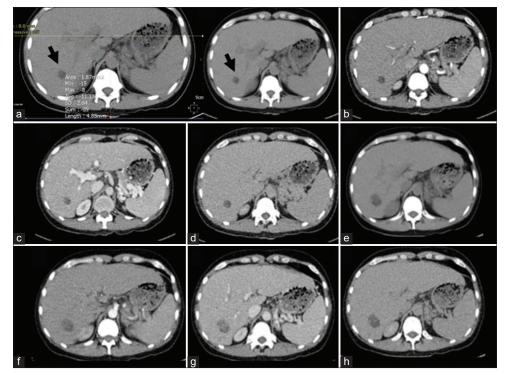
A 64-year-old male with hepatocellular carcinoma presenting with diarrhea. (a-d) multiphase abdominal CT scan showed a nodule (arrow) of -11 HU in non-contrast (a), late arterial (b), venous (c), and delayed phase (d and c). (e and d, h and f) Follow-up examination 3 months later showed that the nodule had enlarged in non-contrast (e), late arterial (f), venous (g), and delayed phase (h) with enhancement in late arterial phase (f and e) and washout in the delayed phase (h and f).
